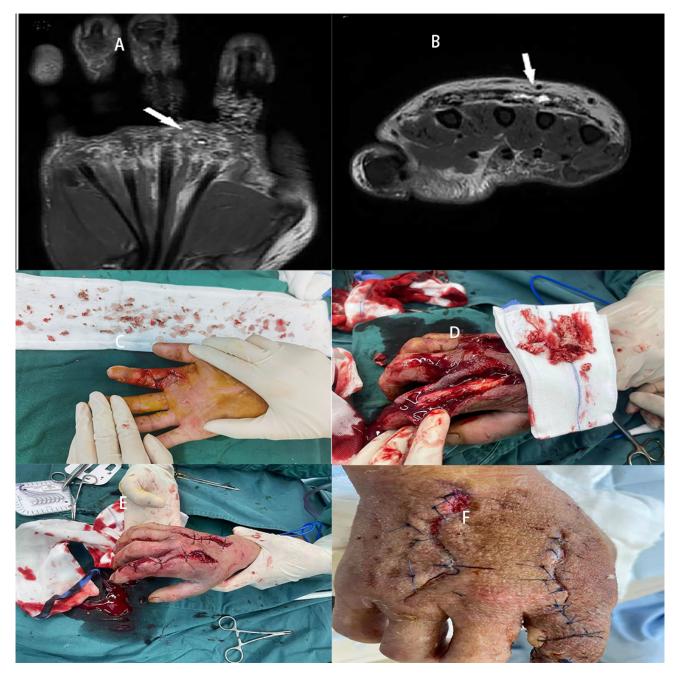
Preoperative MRI images and intraoperative pictures. (A,B) Abnormal signals can be seen on the dorsal side of the second metacarpophalangeal joint of the right hand, with high signals on T2WI (arrows). Debridement and irrigation procedures (C–F), (C) index finger; (D) the dorsal part of the right hand; (E) the wound was sutured, the skin flap was accomplished, and bone cement was placed at the finger web of the right index; (F) Wound condition 2 weeks after operation.
